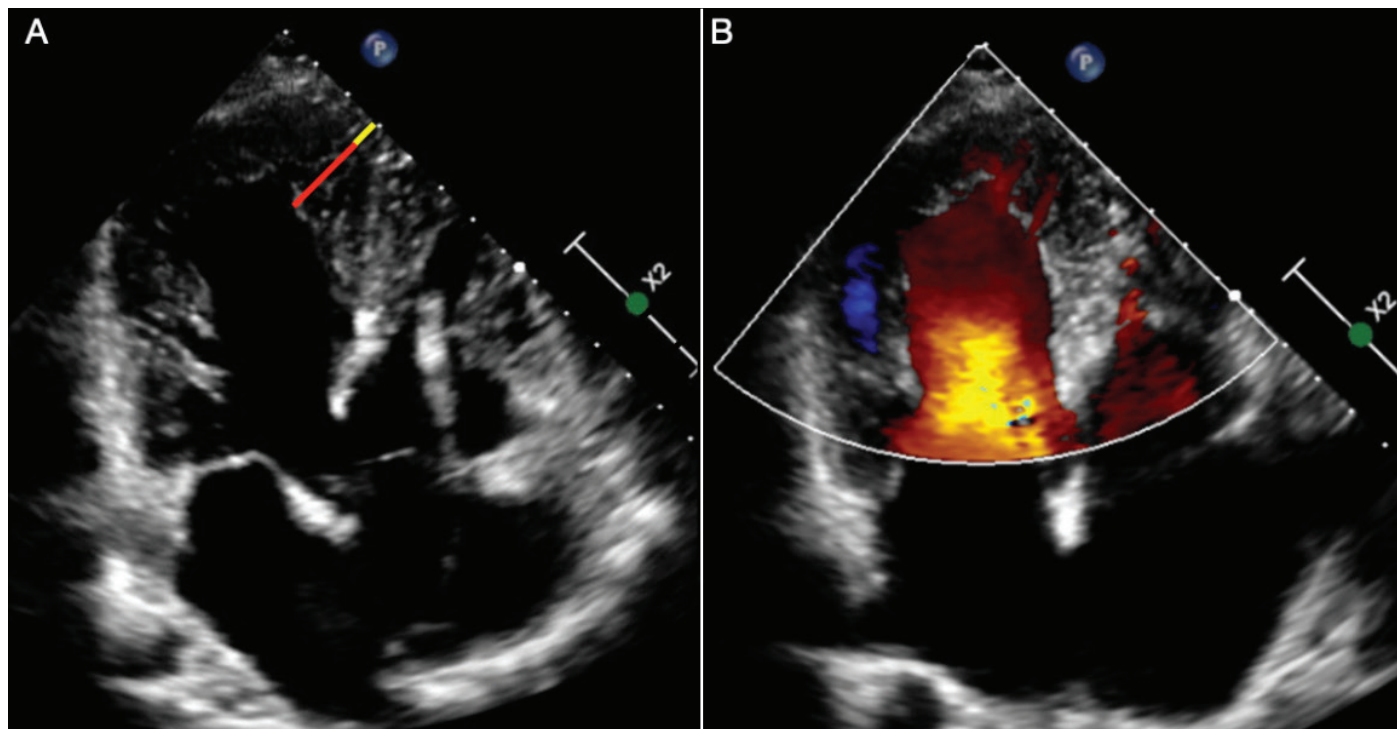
Stöllberger criterion with transthoracic echocardiography in a 35-year-old male patient with biventricular hypertrabeculation and systolic dysfunction who had an implantable cardioverter-defibrillator due to ventricular tachycardia. (A) In the apical view at end-diastole, the noncompact layer (red line) / compacted layer (yellow line) ≥ 2 , and trabeculations and myocardium move simultaneously with the same echogenicity. (B) Blood flow in intertrabecular recesses visualized with color Doppler.
